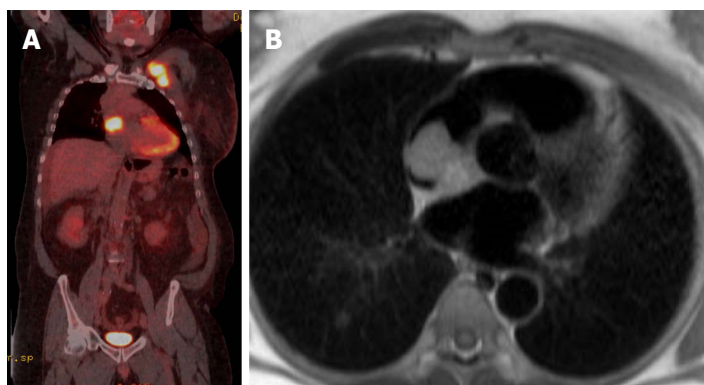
M staging. A: M staging: Coronal PET-CT image of patient with lymphoma with unexpected cardiac involvement; B: Axial T1-weighted image at the level of interatrial septum shows well defined mass attached to the atrial septum and nearly fills the right atrium and was proved to be lymphoma. PET: Positron emission tomography; CT: Computed tomography.
